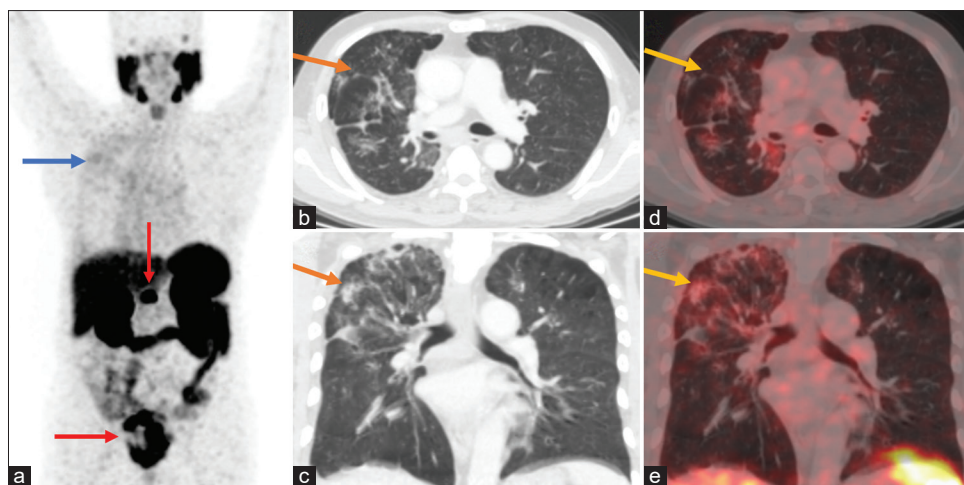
This is a case of a 72-year-old patient with adenocarcinoma prostate with Gleason score 4+4=8 and serum PSA of 208 ng/ml presented with back pain. ^{68}Ga PSMA PET/CECT scan was done for staging. MIP image (a) shows increased tracer uptake in prostatic mass and lumbar vertebral lesion (red arrows), low grade tracer uptake (SUVmax 4.63) is seen in upper lobe of right lung (blue arrow). Fused and CT images in axial and coronal planes show low grade tracer uptake in a few patches of consolidation and ground-glass opacities with intermittent reticular thickening in right lung (b-e; respectively)
